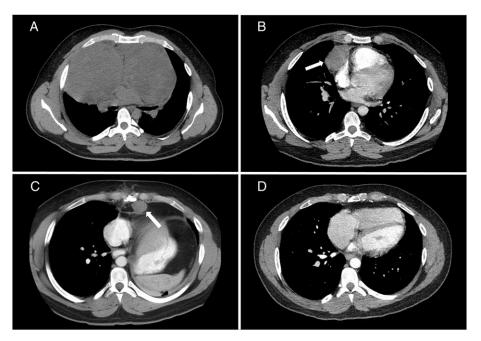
(A) Computed tomography (CT) scan at diagnosis, with evidence of a large mediastinal bilobed mass. (B) CT after first-line etoposide/ifosfamide/cisplatin with evidence of partial response with residual disease measuring 3.4×5.7 cm and 3.6×6.3 cm. (C) CT after first-line chemotherapy followed by surgical resection of residual with evidence of a new enlarged paracardiac node suggestive of recurrent disease. (D) CT 3 years post-stereotactic body radiation therapy showing sustained complete response.
